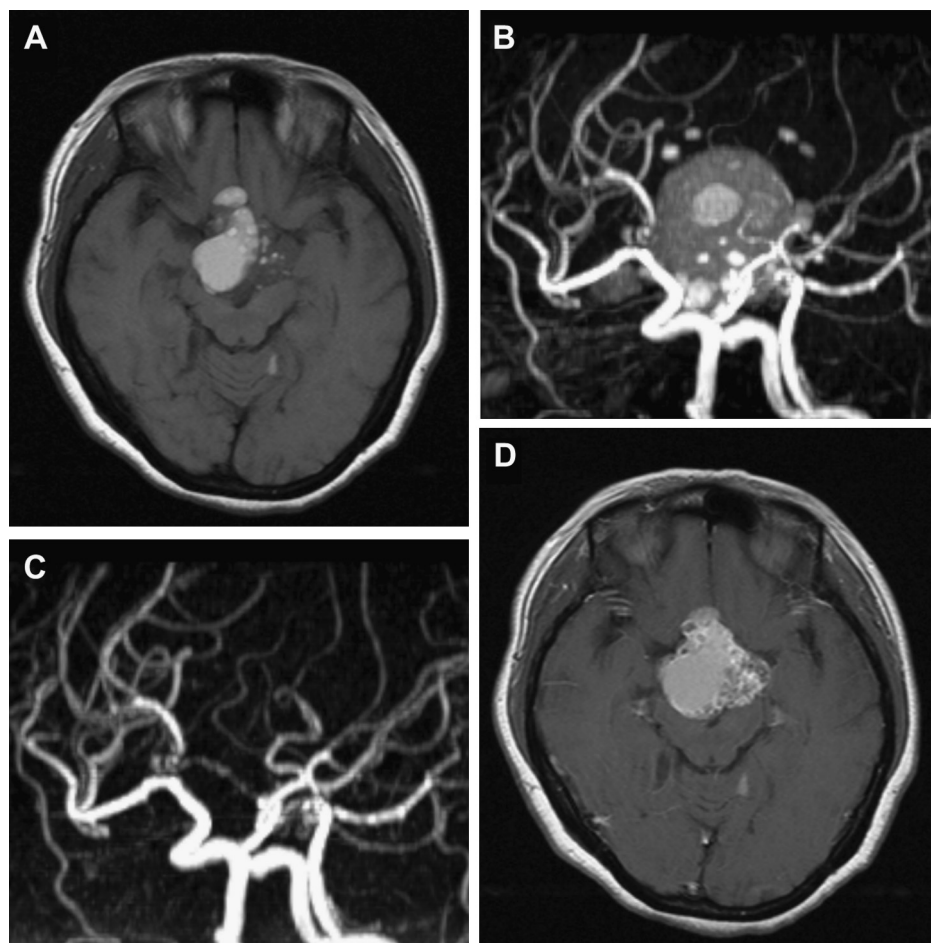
Parasellar tumor in a 44-year-old female who presented with blurred vision for 2 years. (A) Axial T1-weighted image through the suprasellar cistern showing a lobulated mass containing multiple short T1 nodules in the midline. (B) Oblique sagittal conventional three-dimensional (3D) time-of-flight magnetic resonance (TOF MR) angiogram of the circle of Willis showing multiple aneurysm-like structures in the brain. For the selectively displayed arterial anatomy, both observers assigned the image quality scores of 2. (C) Oblique sagittal subtraction 3D TOF MR angiogram showing a normal circle of Willis. For the selectively displayed arterial anatomy, both observers assigned the image quality scores of 0. (D) Gadolinium-enhanced axial T1-weighted image showing multiple ring-enhancing cystic structures around the mass. The aneurysm-like structures in the conventional 3D TOF MR angiogram (B) are thought to be short T1 components within a tumor rather than true aneurysms with flow-related enhancements.
